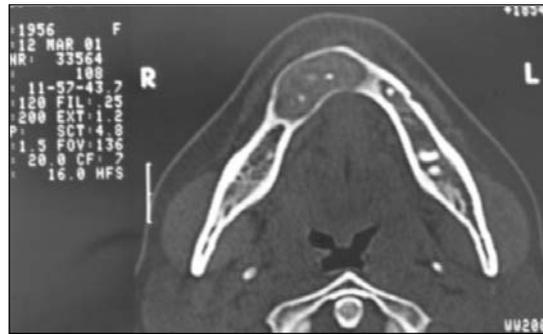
Radiographic view of the lesion
